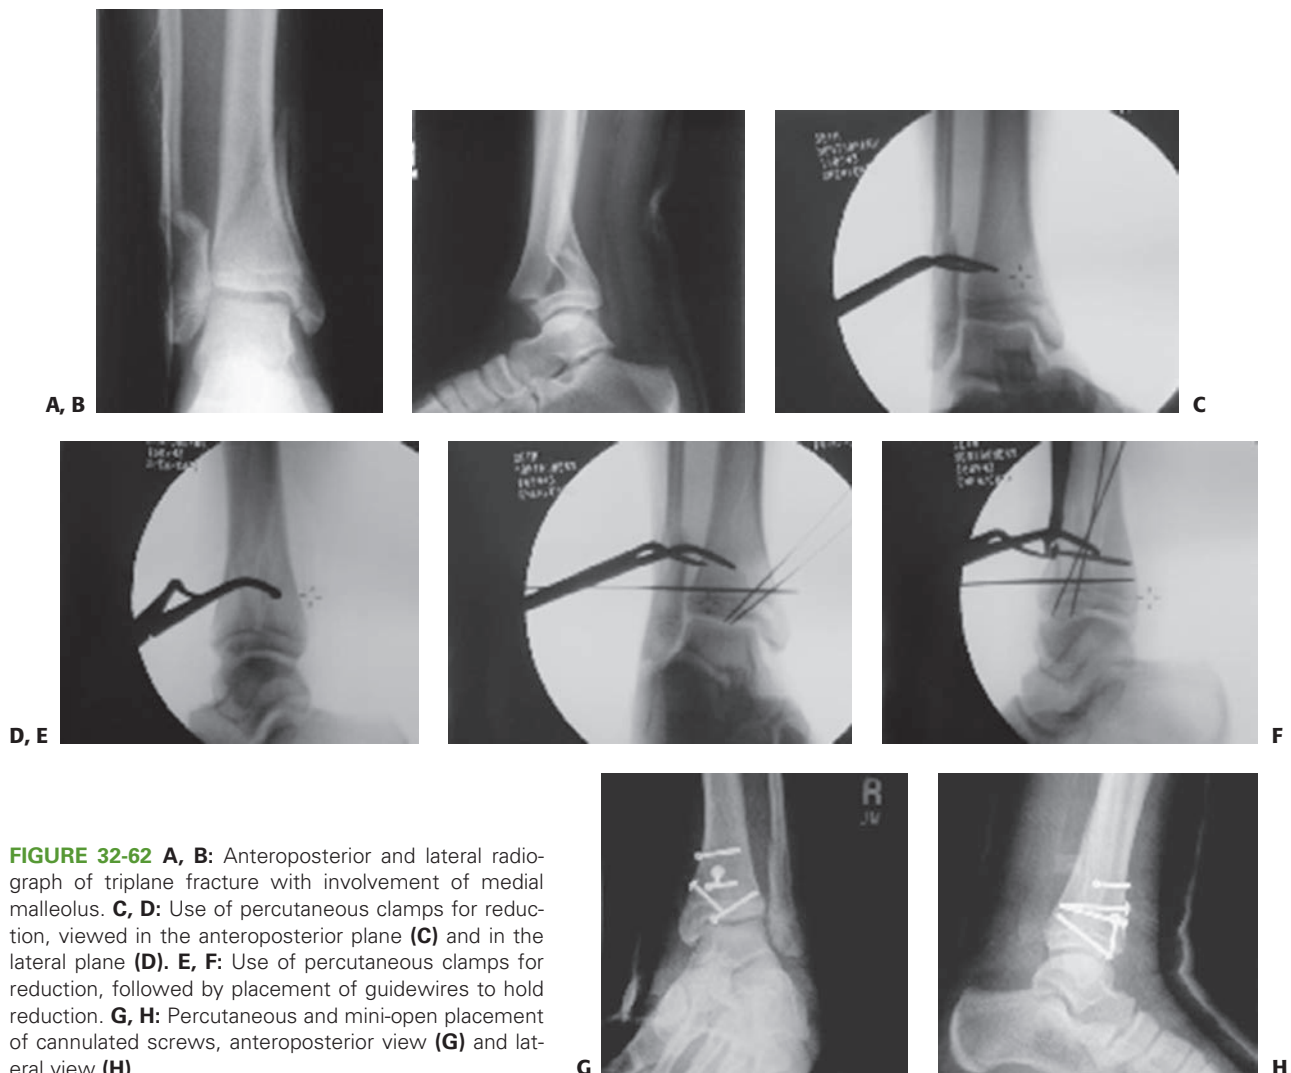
A, B: Anteroposterior and lateral radiograph of triplane fracture with involvement of medial malleolus. C, D: Use of percutaneous clamps for reduction, viewed in the anteroposterior plane (C) and in the lateral plane (D). E, F: Use of percutaneous clamps for reduction, followed by placement of guidewires to hold reduction. G, H: Percutaneous and mini-open placement of cannulated screws, anteroposterior view (G) and lateral view (H).
